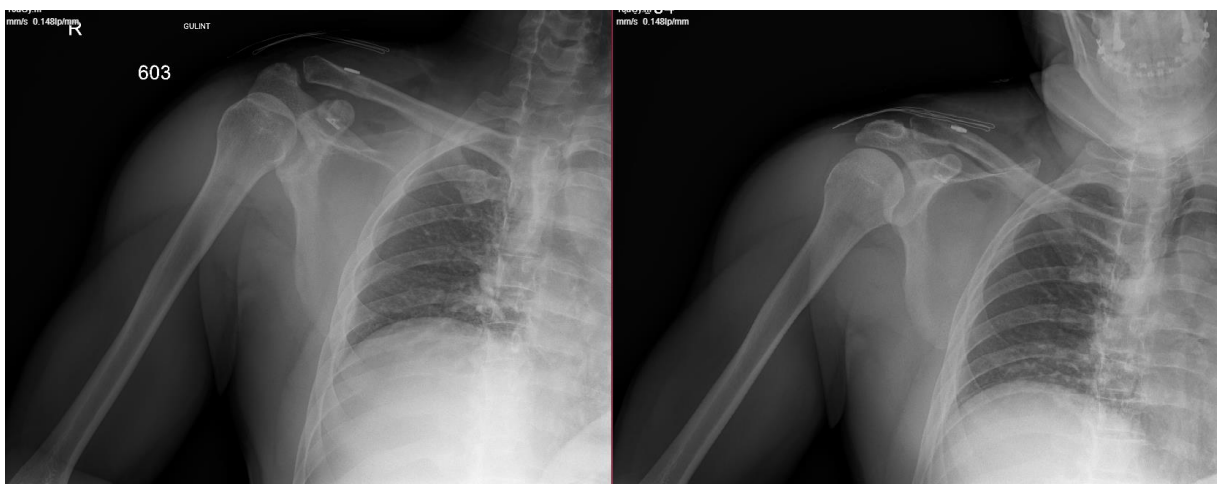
30.12.2021 X-Ray Right Shoulder
